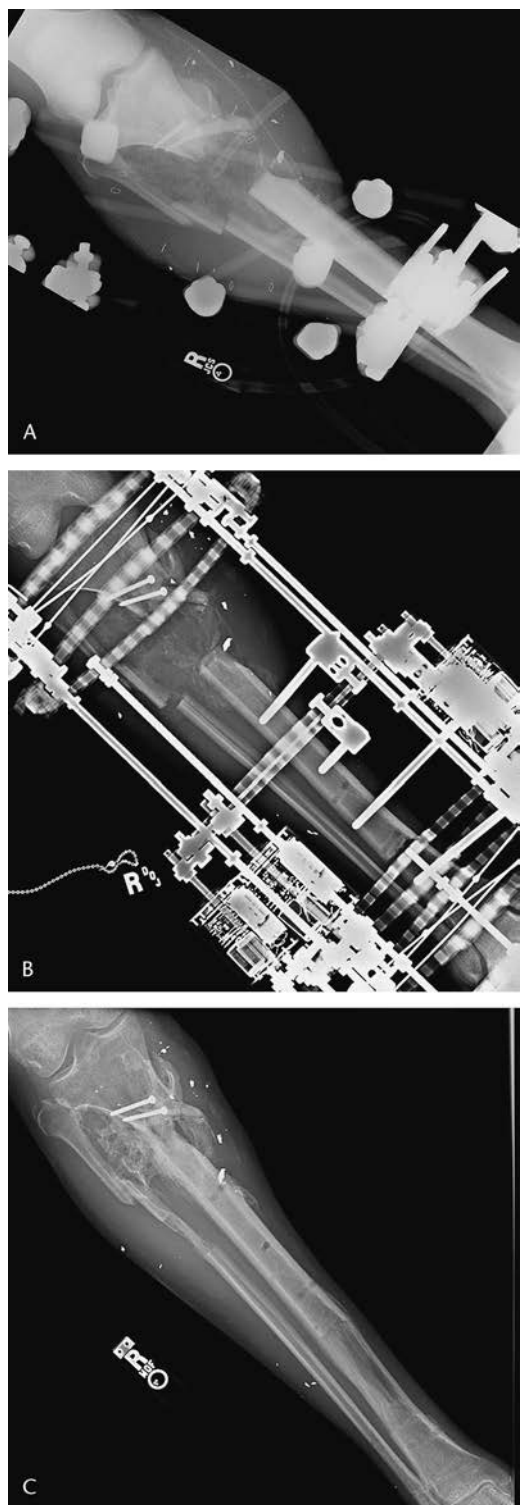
(A) Anteroposterior radiograph of proximal third tibia fracture after initial stabilization. (B) Anteroposterior radiograph of proximal third tibia fracture after circular fixator. (C) Anteroposterior radiograph of proximal third tibia fracture after osseous union.
